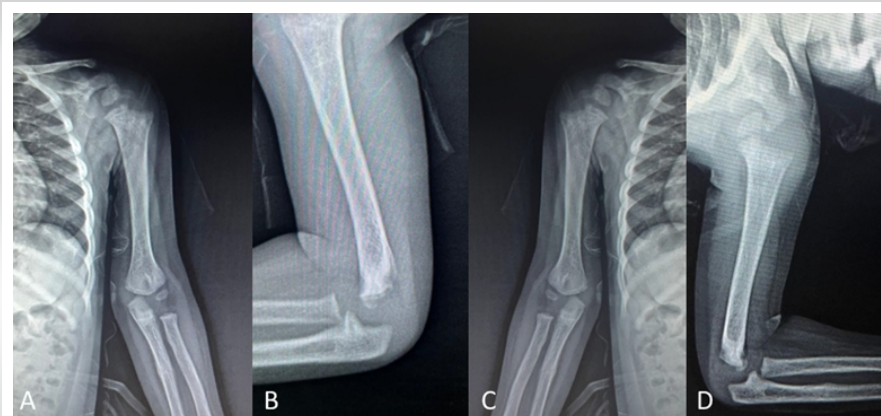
(a and b) Anteroposterior view and lateral view of left elbow showing 1-year post-trauma radiograph with excellent remodeling and good alignment. (c and d) Anteroposterior view and lateral view of right elbow showing 1-year post-trauma radiograph with excellent remodeling and good alignment.
